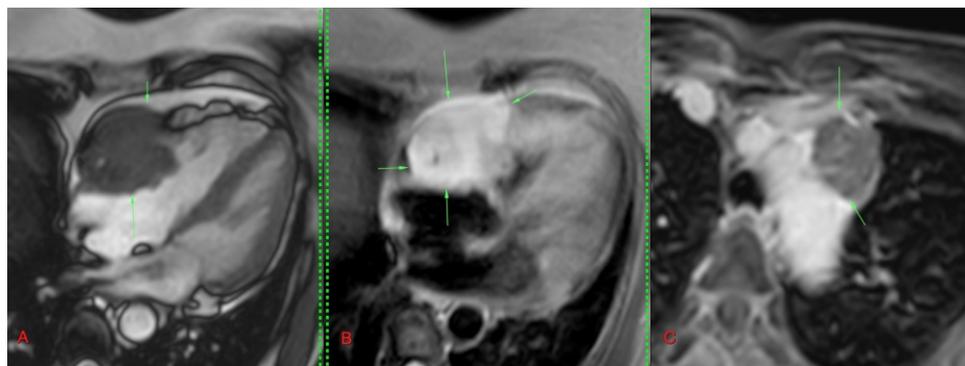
(A-C). Cardiac MRI. Four-chamber cine (A), four chamber STIR (B) and axial chest (C) show a mass (green arrows in A and B) involving the right atrium and ventricle with an enlarged lymph node in the left para-aortic region (arrow in C).
